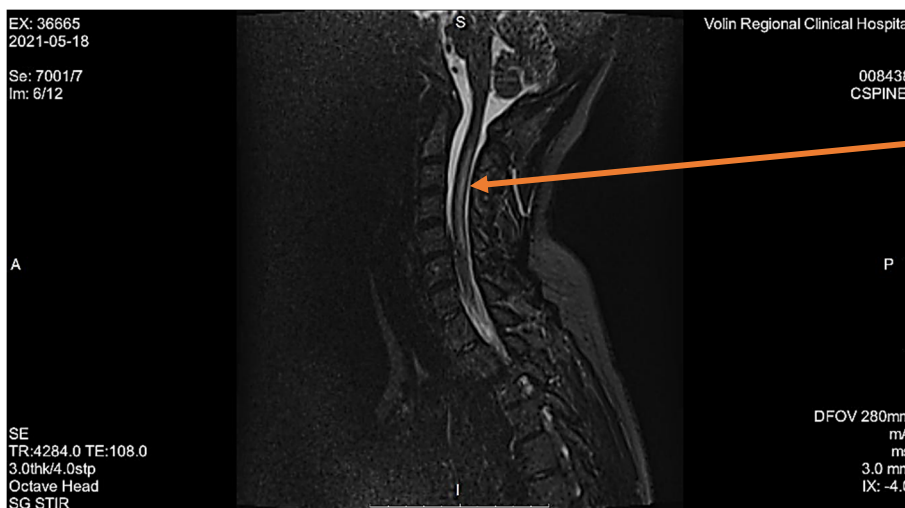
Magnetic resonance imaging of the cervical spine on May 18, 2021, sagittal plane, STIR sequence. Longitudinal T2 hyperintensity in the posterior cords of the spinal cord at the C2-Th1 level (arrow)
